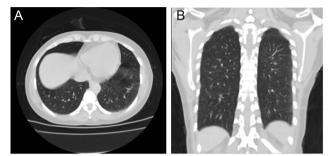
High-resolution computed tomography of the chest after 42 days of antibiotic treatment. (A-B) Axial and coronal section of the lung showing the complete resolution of left basal consolidation, pleural effusion, and atelectasis. Source: Authors.
